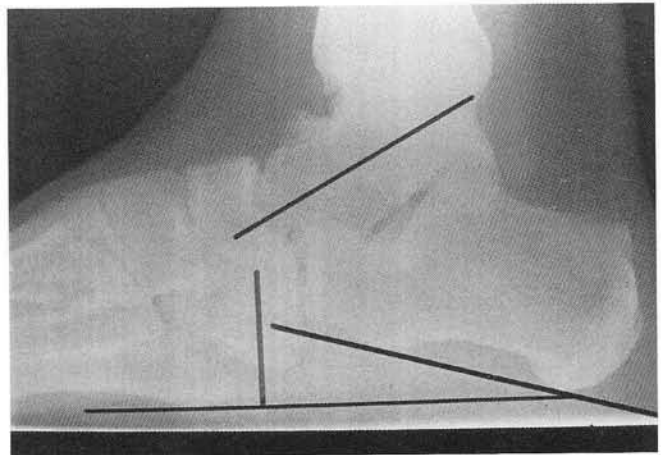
Neutral position lateral radiograph. Note the significant improvement in the subtalar and midtarsal joint alignment. This was the desired position of fusion for this patient.
